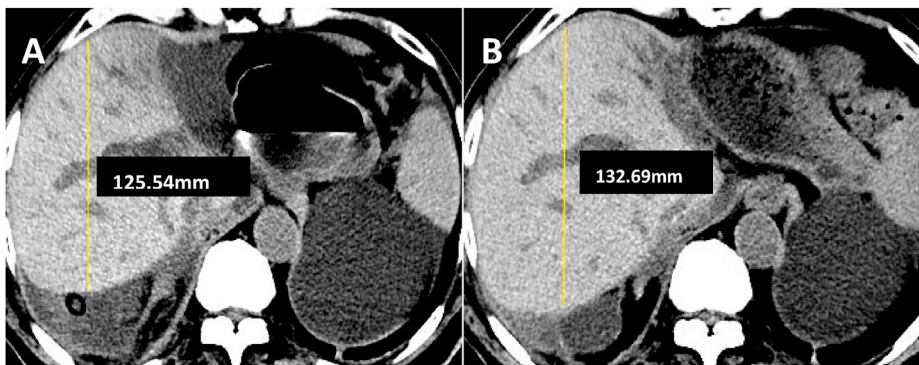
Postoperative abdominal computed tomography of the graft. On postoperative day 14 (B), computed tomography revealed a 5.6% increase in liver volume compared to postoperative day 7(A), indicating satisfactory liver growth.
